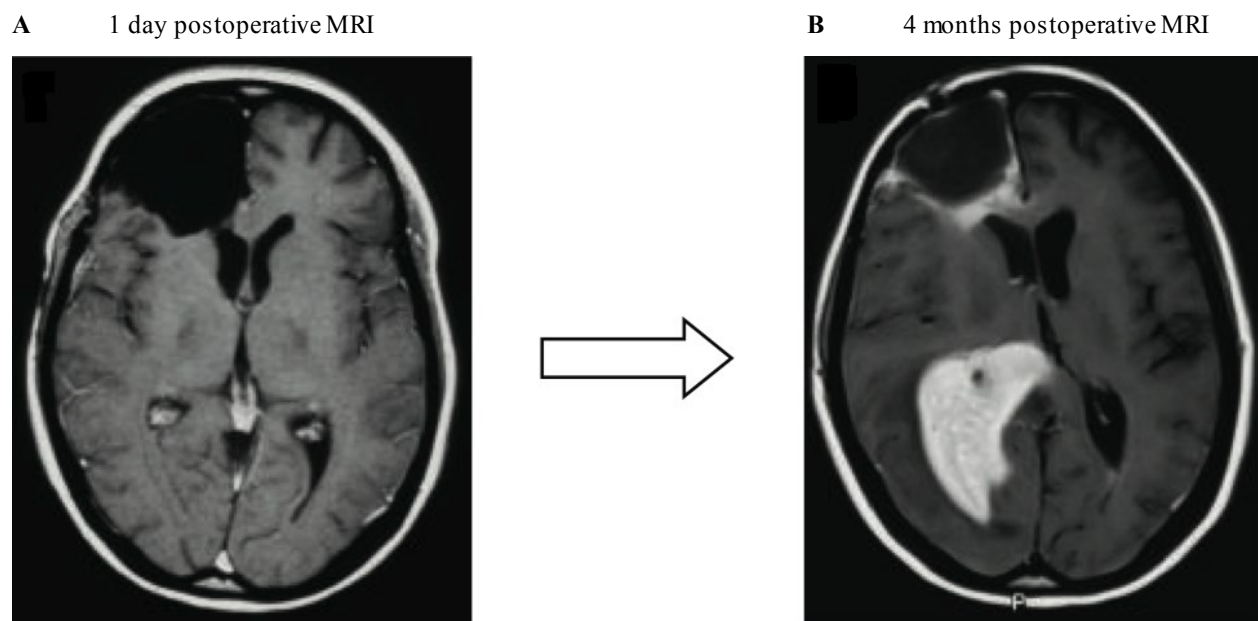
MRIs showing aggressive invasion of GBM. (A) MRI showing the resection hole one day after surgical resection of a right frontal GBM. (B) MRI of the same patient collected four months after surgery, fractionated radiotherapy, and chemotherapy with temozolomide (TMZ). A new tumor has formed and there is evidence of tumor reformation at the site of resection, indicating local relapse. Figure adapted from Martínez, R., 2012 [2] with modification.
